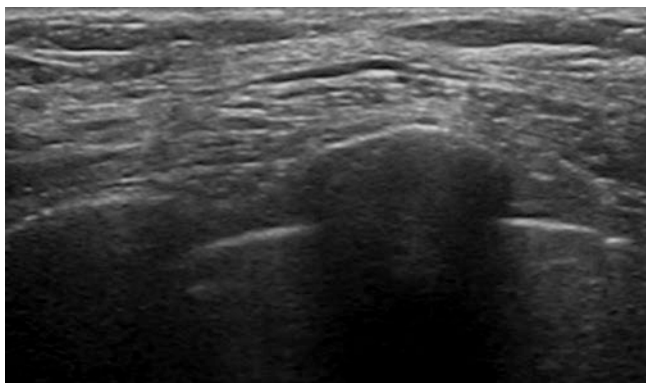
Sonographic appearance of a mastectomy. The skin, subcutaneous tissue, and the pectoral muscle on the chest wall can be appreciated
